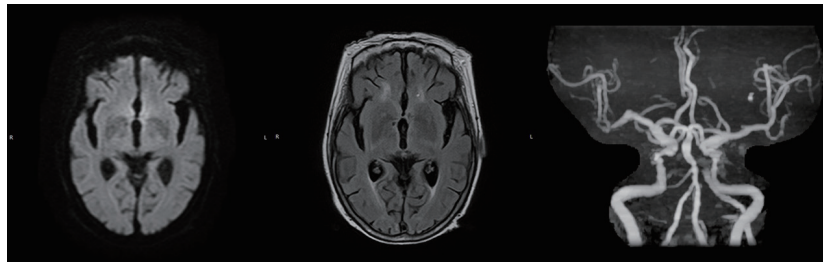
Presence of some tiny hyperintensities on T2 FLAIR image in the periventricular and subcortical white matter region but no hyperintensities on Diffusion-weighted images. There was no occluded vessel noted in Magnetic Resonance Angiography
